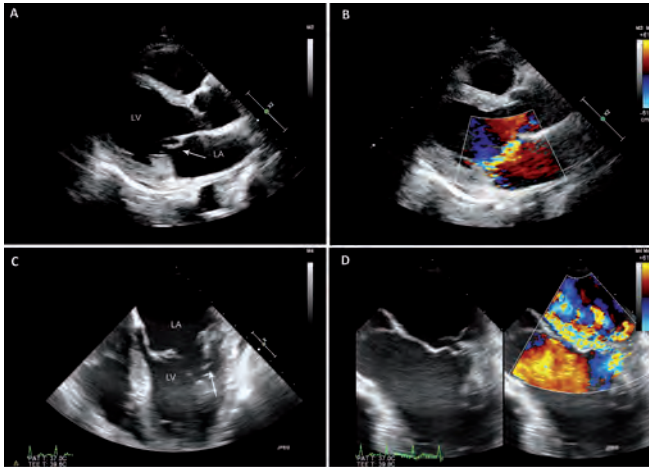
Transthoracic (panels A, B) and transoesophageal (Panels C, D) echocardiography demonstrating a large vegetation on the mitral valve (arrow) and severe eccentric mitral regurgitation (Panels B, D). LA - left atrium, LV - left ventricle.
